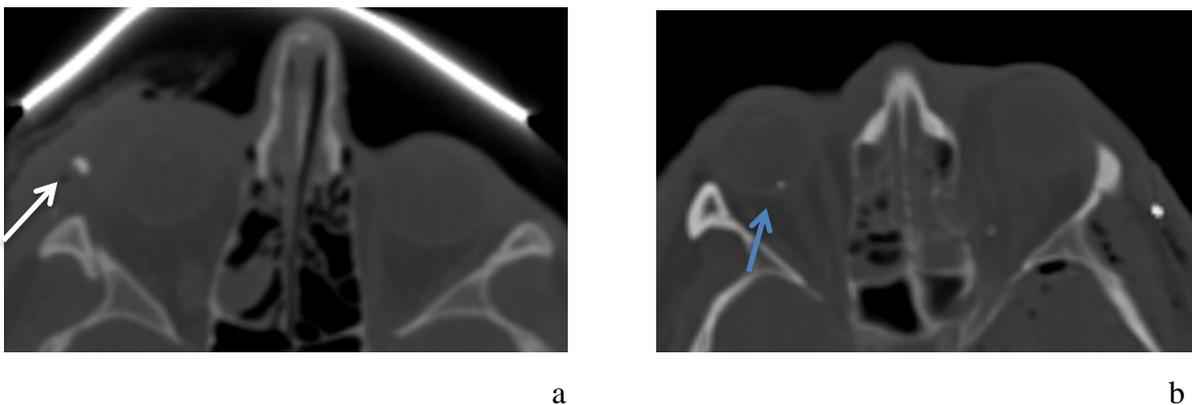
(a/b): Foreign body pre-orbital, right eye (15-year-old boy). CT, transverse section (a): Metallic foreign body (white arrow) in edematous tissue with high density and radiopaque. Metallic foreign body, right eye (40-year-old male). CT, axial image (b): Metallic foreign body within the right conus (blue arrow) at the rear bulbar wall of the right globe. Left globe appears unshaped.
